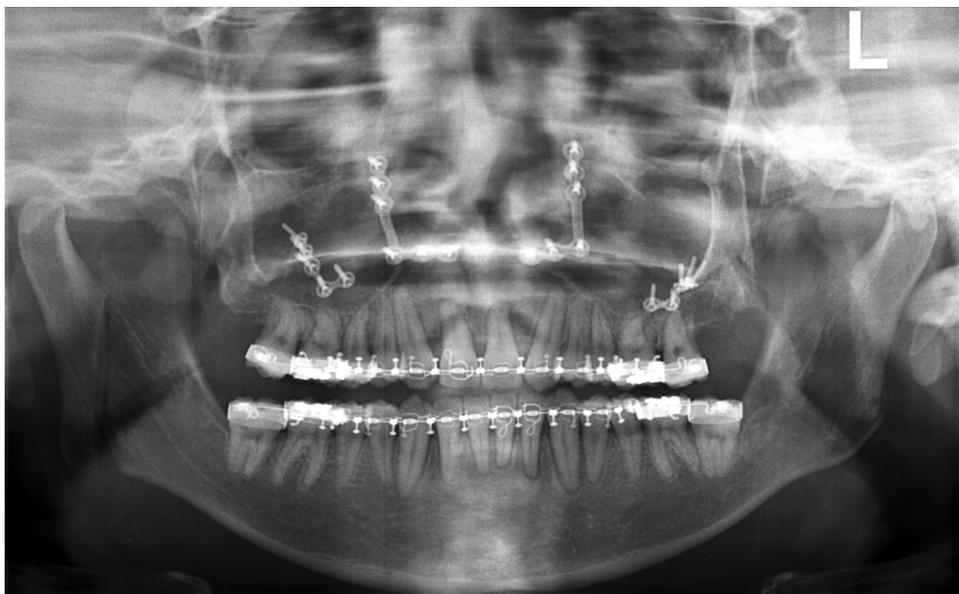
Panoramic radiograph 1 week postoperatively.
